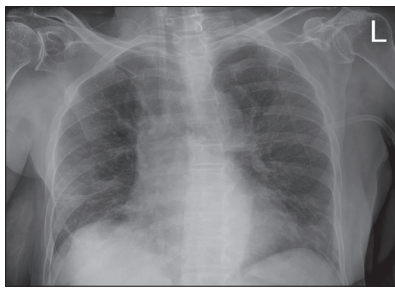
Case 2 – chest X-ray scan shows extensive bilateral pulmonary consolidations involving both lower lobes with a zone of reduced pericardial transparency of the left lung
